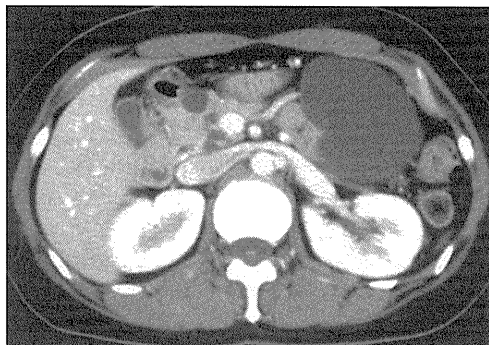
Abdominal computed tomography shows several cystic lesions in the pancreas (32-year-old female).
